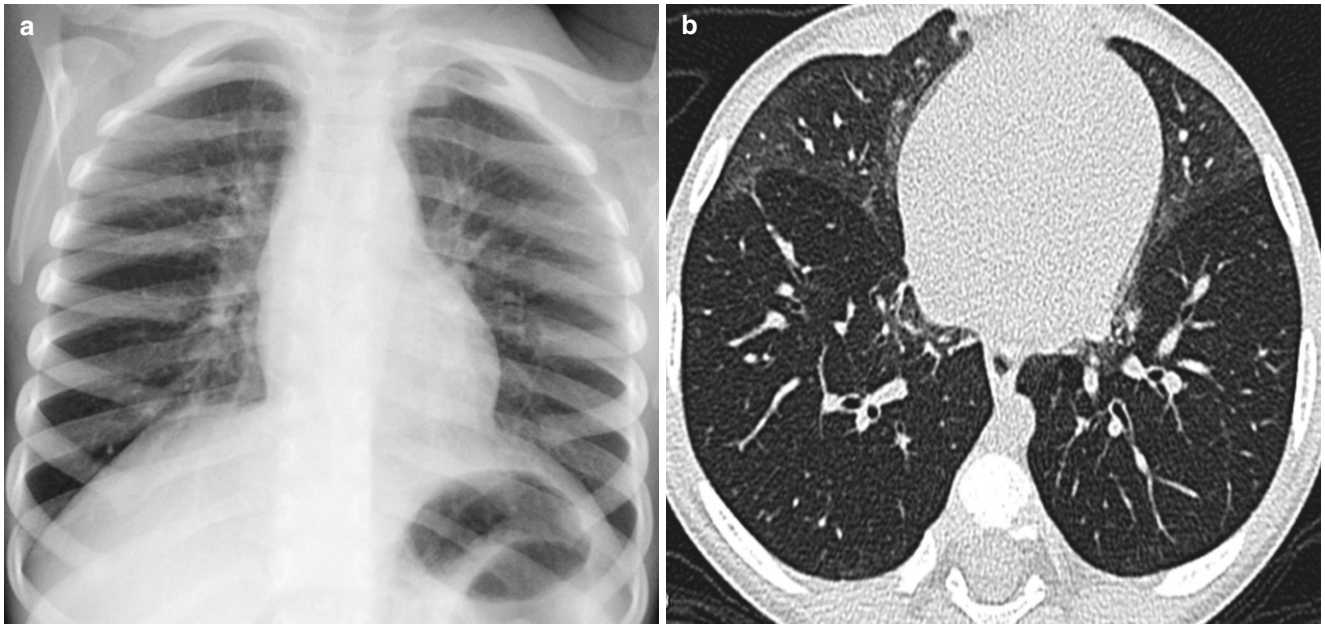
Neuroendocrine cell hyperplasia of infancy in a 5-month-old boy who presented with persistent tachypnea, retractions, hypoxemia and crackles. (a) Frontal chest radiograph shows pulmonary
